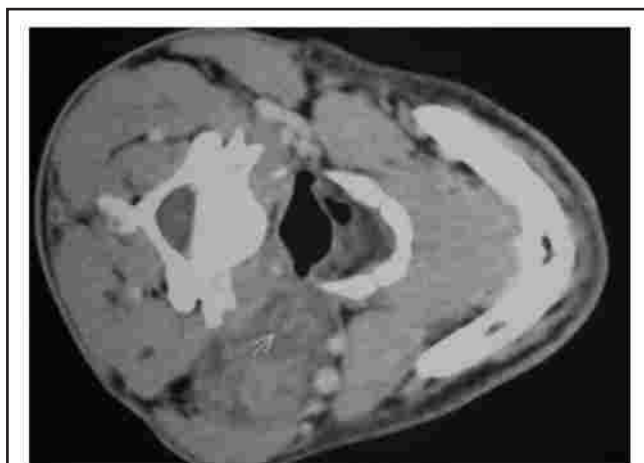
An axial post-contrast CT scan showing left-sided parapharyngeal space non enhancing lesion with the common carotid artery and jugular vein displaced together in an anterior direction.
